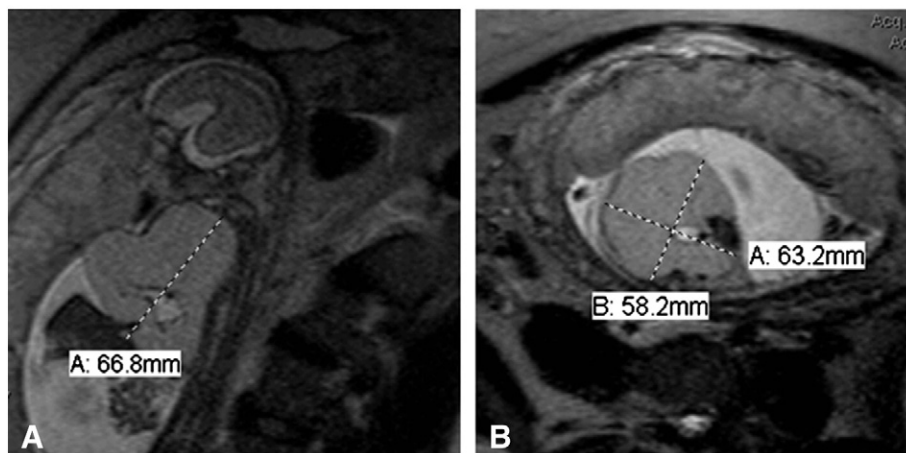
T2-weighted fetal MR single shot imaging with additional bFFE images of a 22-3/7 weeks GA fetus. Sagittal (A) and axial (A) views demonstrate an extremely large, right side based chest mass with marked mass effect, including displacement of the heart and mediastinum, and inversion of the hemidiaphragms, and very little lung tissue visible on the left. There is a central high signal branching structure at the right hilum that is very suggestive of a mucocele and central bronchial atresia of the right lung. Measured CVR = 9.
